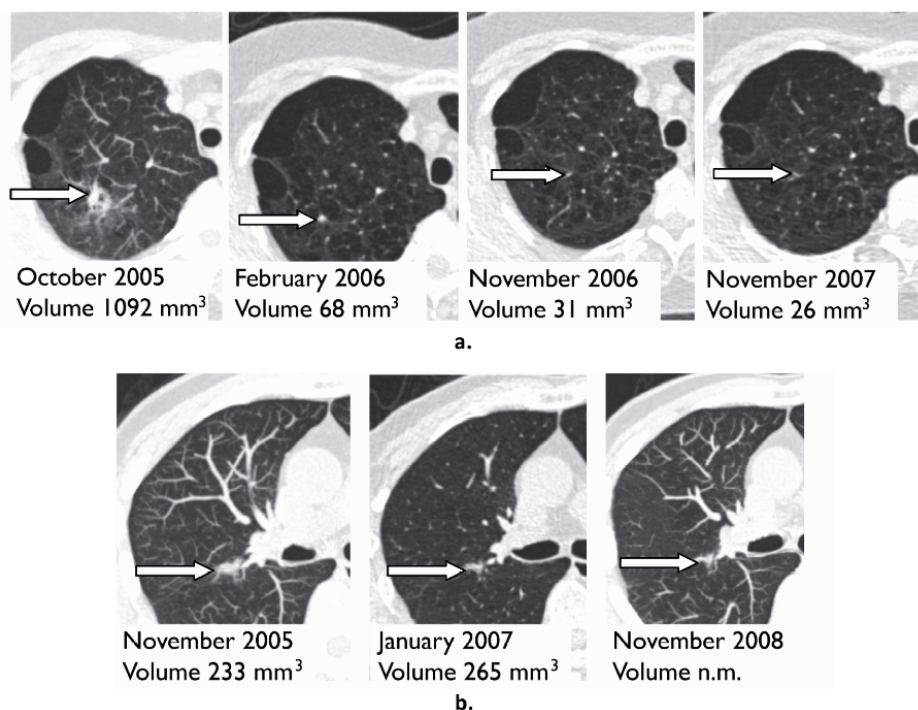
Examples of downward classified benign lesions. Downwards adjusted lesion in a 54-year-old female (a) and a 72-year-old male (b). Axial computed tomography (CT) shows lesions with baseline volumes of 1092 mm³ (a) and 233 mm³ (b). Reasons for adjustment were appearance as fibrosis or scar making the radiologist to adjust the screen result from positive to indeterminate to see what happens in three months (a), and attachment to the fissure and appearance more like fibrosis, making the radiologist to adjust the screen result from indeterminate to negative (b).
